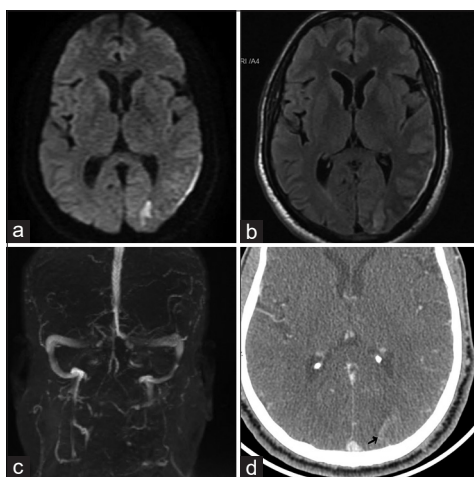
(a) Diffusion-weighted image of the patient showing left occipital infarct; (b) T2-weighted FLAIR image showing the thin rim of SDH in the left cerebral convexity with the occipital infarct; (c) the dural venous sinuses showing normal flow; (d) CT angiogram delayed phase showing a linear hyperdense vessel-like structure within the infarct with a few filling defects noted within (black arrow)
